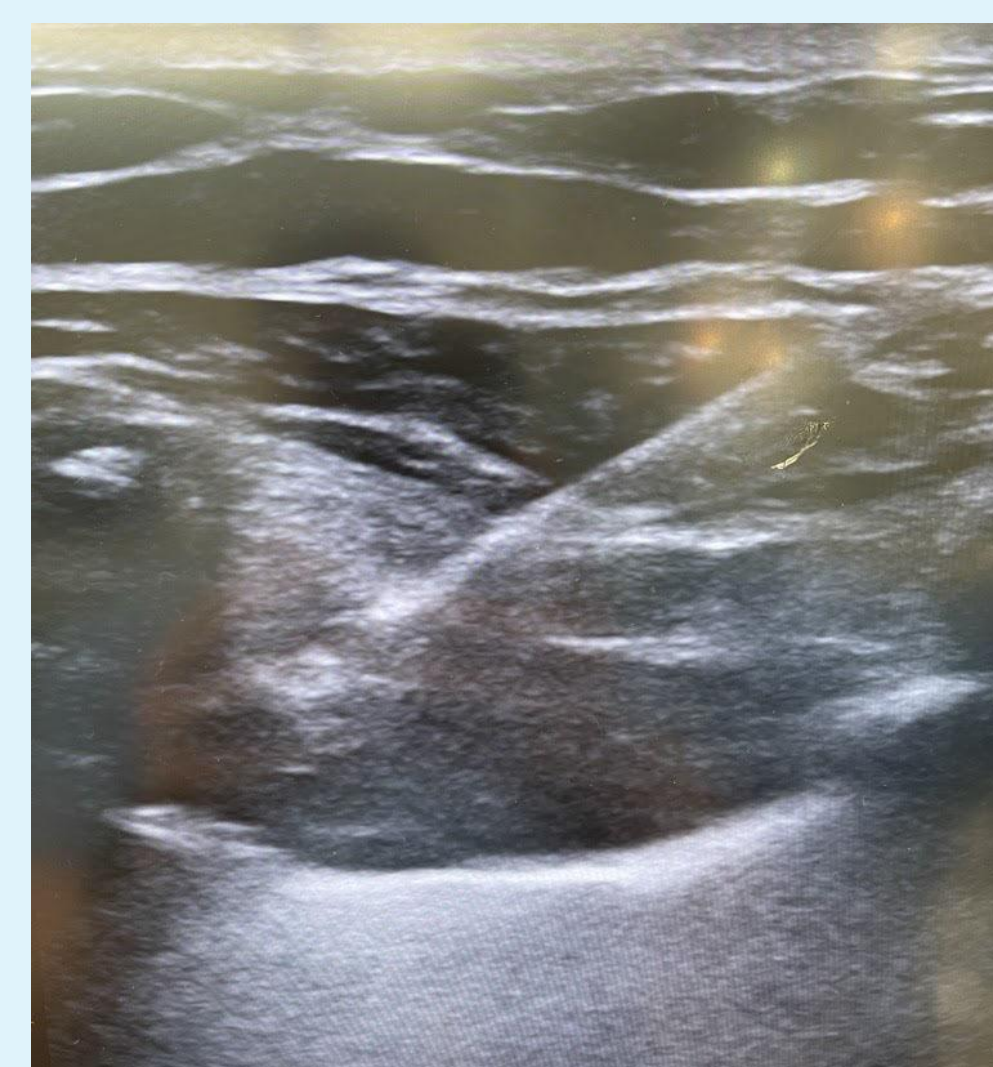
Ultrasound imaging showing anatomy and needle position during TTP block. Fig 4b. Ultrasound imaging with false color overlay showing anatomy and needle position during TTP block.
